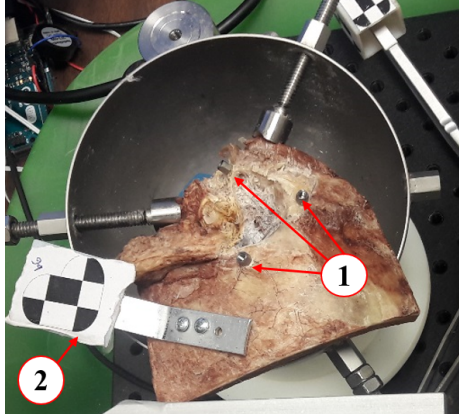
Each bone was equipped with: 1) fiducials and 2) a unique tracking marker so that the tracking software could measure the location of the bone and a registration could be performed between CT scans of the bone and the optical tracking measurements.
